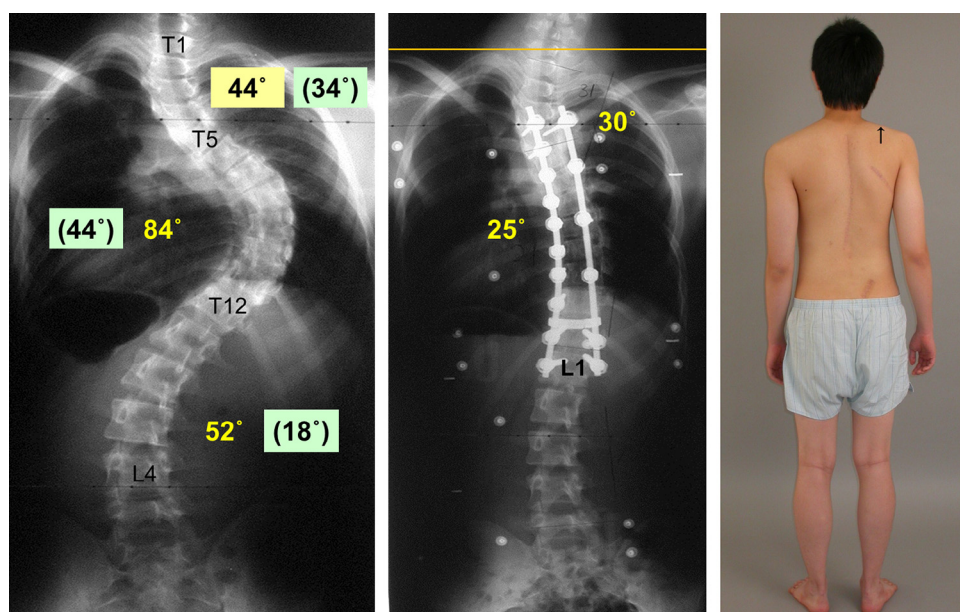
Case showing the difference between subjective symptoms and radiographic findings with regard to shoulder imbalance. (Left) 17-year-old male patient showed a rigid proximal thoracic curve that required correction and fusion of the PT curve, following classical indications. (Middle) However, the PT curve was left unfused. At 1.5 years postoperatively, the left shoulder was found to be elevated on radiographs. (Right) However, the patient complained of elevation of the right shoulder instead of the left one.
